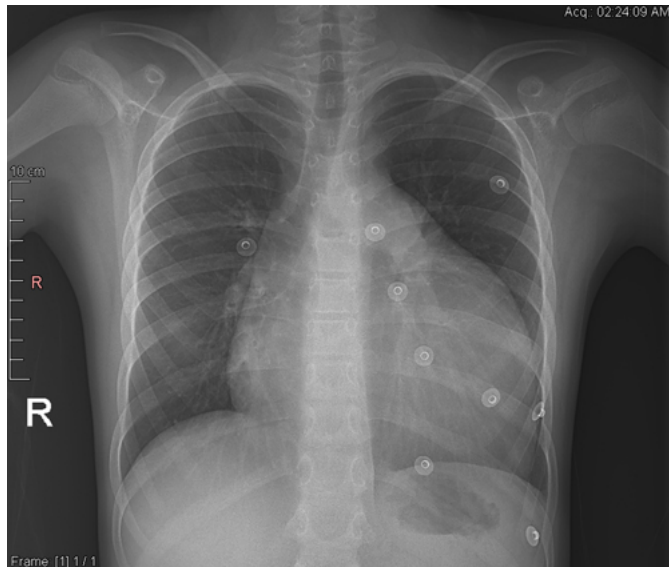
Chest X-ray showing cardiomegaly with marked dilation of the pulmonary arterial trunk, with no evident airway nor parenchymal disease.
